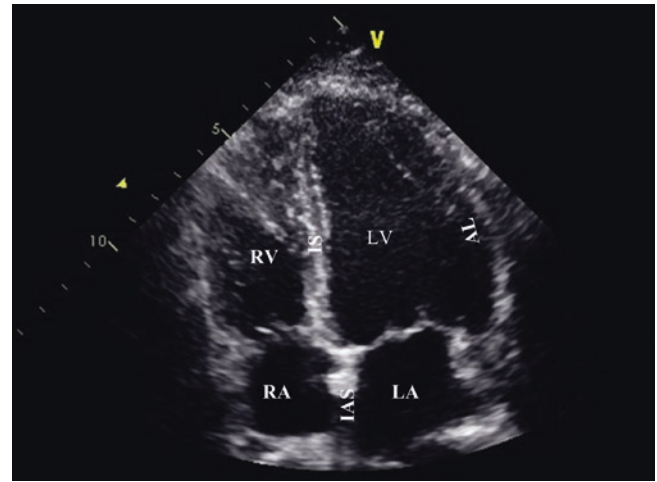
Apical four-chamber view. The left ventricle (LV), right ventricle (RV), interventricular septum (IS) and the anterolateral wall (AL) of the left ventricle, left atrium (LA), right atrium (RA) and interatrial septum (IAS) are seen. Adequate visualization of the apex is essential for correct estimation of the left ventricular ejection fraction. Apical foreshortening may result in overestimation of the ejection fraction. See also Video 16.5
